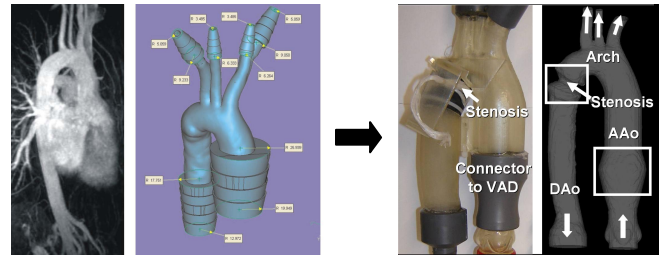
Vessel model manufacturing from the original MR angiography of the aorta (left) and a computer model including added connection adapters (mid). Right: Final RP vessel model with connector to the VAD in the ascending aorta (AAo) and the integrated stenosis in the descending aorta (DAo) and the corresponding isosurface derived from MRI measurements.
